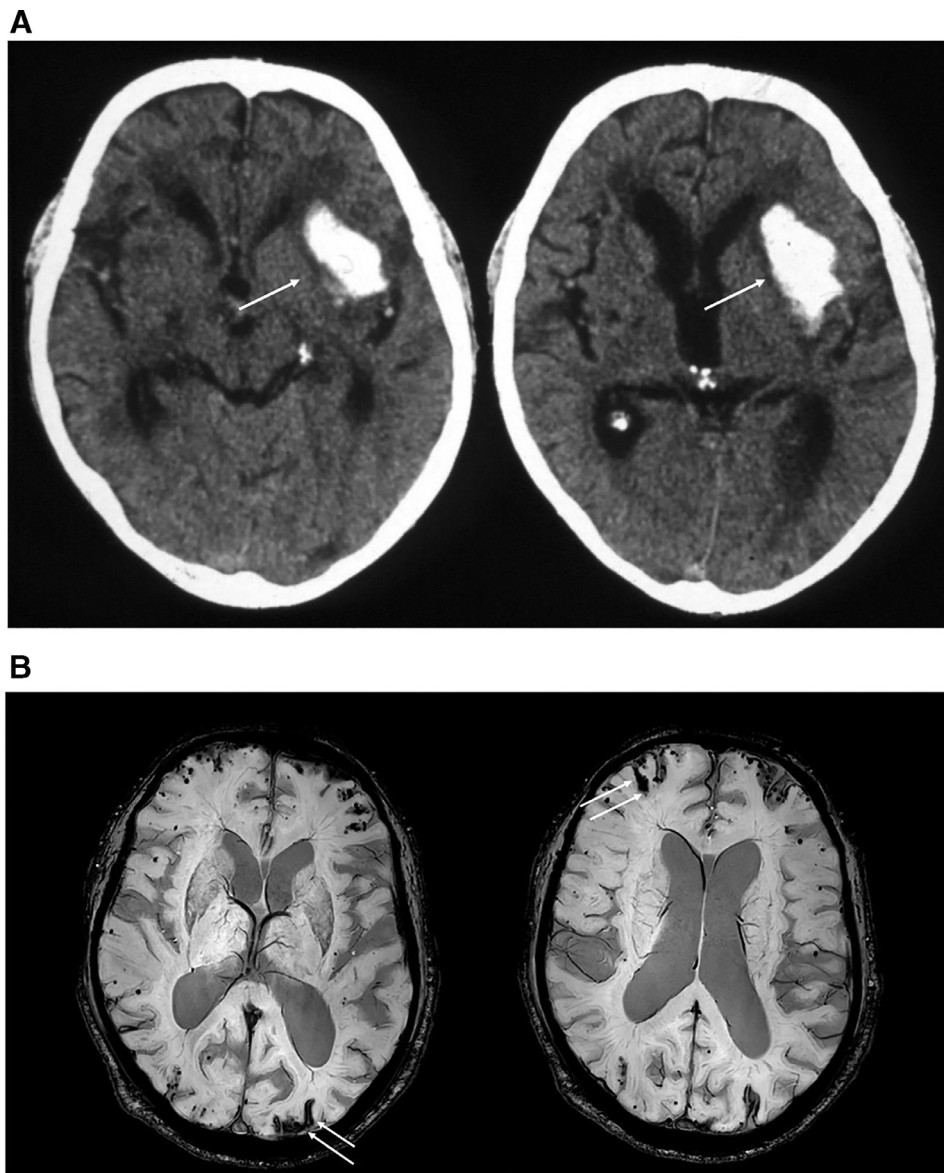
(A). CT scan of spontaneous intracerebral hemorrhage in loco typico (hypertensive “deep” ICH) due to arterial hypertension. Initiation for OAC after blood pressure control is recommended if stroke risk due to AF is high. (B). MRI scan of multiple cortical and subcortical bleeds, frontal and posterior hemorrhage localized to the cortical sulci at the convexity of the brain (convexity subarachnoid hemorrhage). Imaging is highly suggestive of ICH due to cerebral amyloid angiopathy and oral anticoagulation is not recommended.
